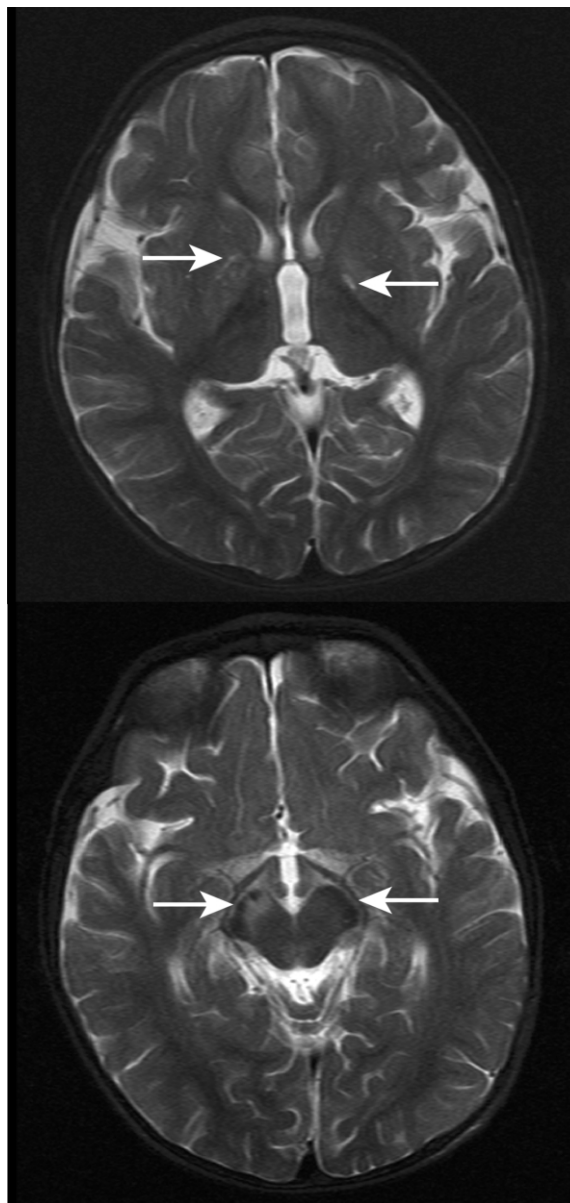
MRI scans made when patient 2 was 14 mo old (T2-weighted images). There is signal abnormality in the brain regions indicated by the white arrows: in the globi pallidi (*upper panel*) and in the midbrain with asymmetrical involvement of the cerebral peduncles (R→L) (*lower panel*). The appearances were considered likely to represent a neurometabolic disorder. No structural abnormality was noted.
